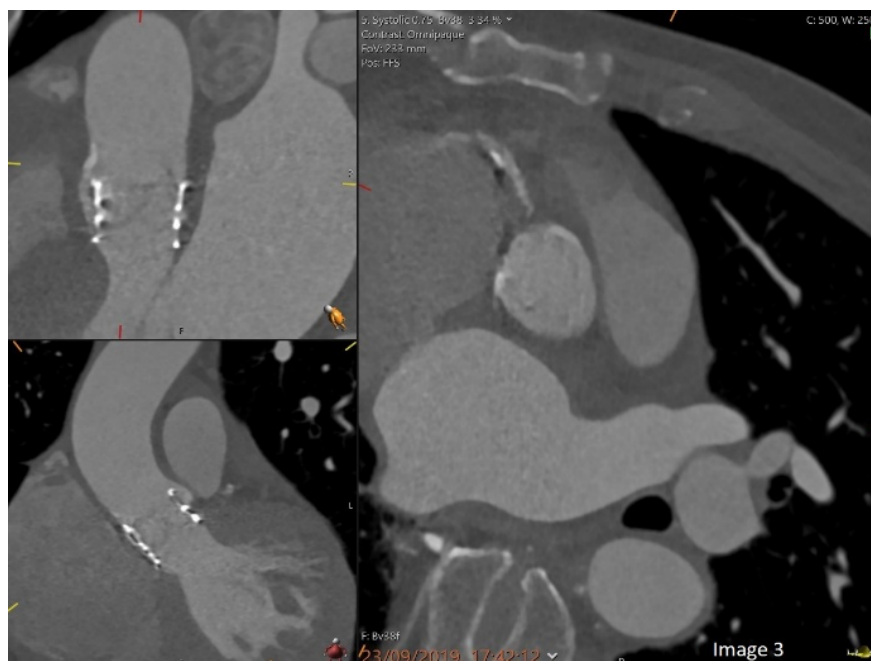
Cardiac computed tomography Figure 4 Transthoracic echocardiogram x plane
